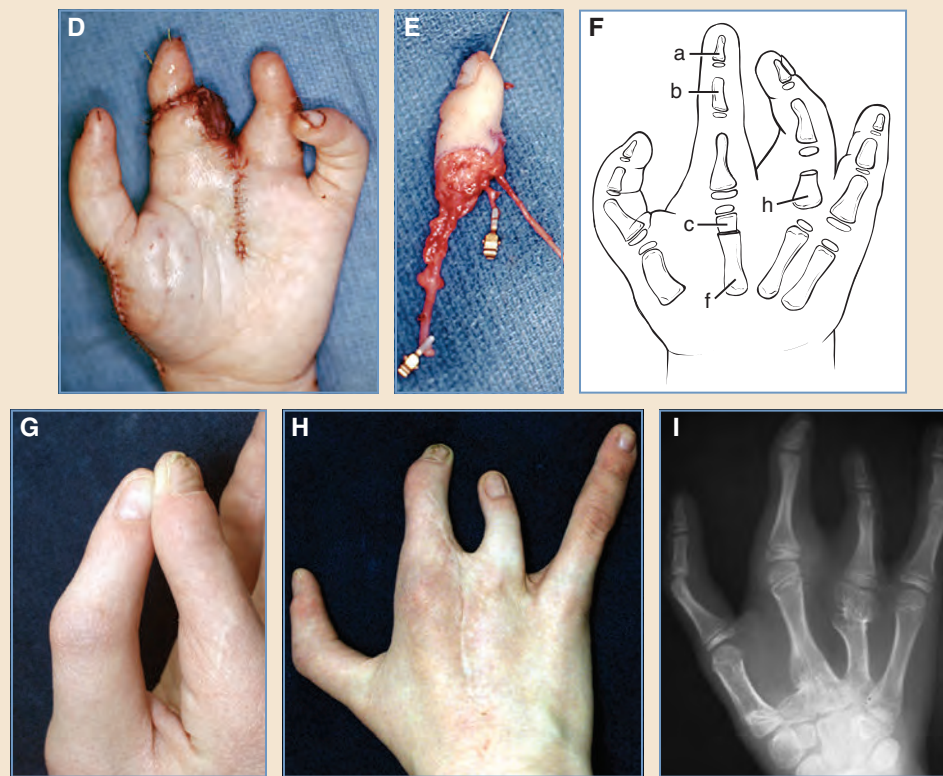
cont'd D-E, At the second stage, the thumb duplication (*a, b*) was transferred on top of the index ray to make a longer and more complete digit. Nerves and tendons were all joined. G-I, The patient developed a very functional pinch between the long (and untouched) triphalangeal thumb and the index finger. Her hand and the radiograph are seen at skeletal maturity. The patient has become a very confident young woman and, in fact, has won regional New England piano competitions.
